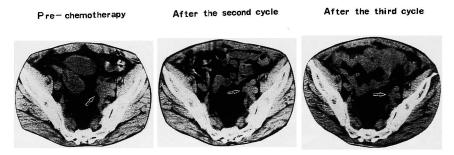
CT scan of pelvic cavity before and after chemotherapy. After the second and third cycle, and remarkable remission was introduced (arrows).
